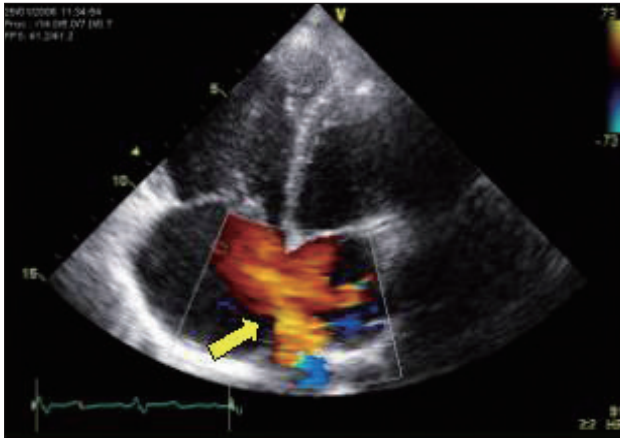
Transthoracic echocardiography showed a large atrial septal defect (arrow), ostium secundum type (32-38 mm).
